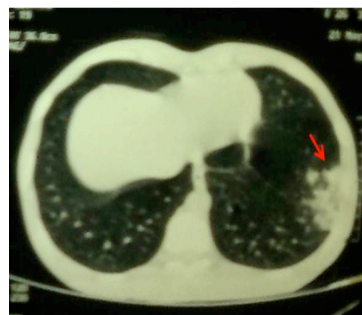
Left lower zone consolidation on HRCT Chest
